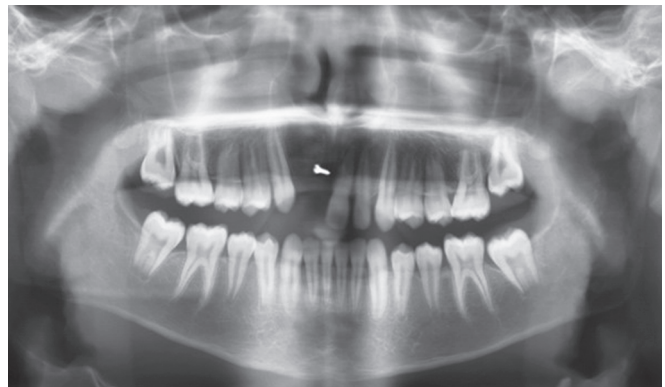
Postoperative orthopantomogram
